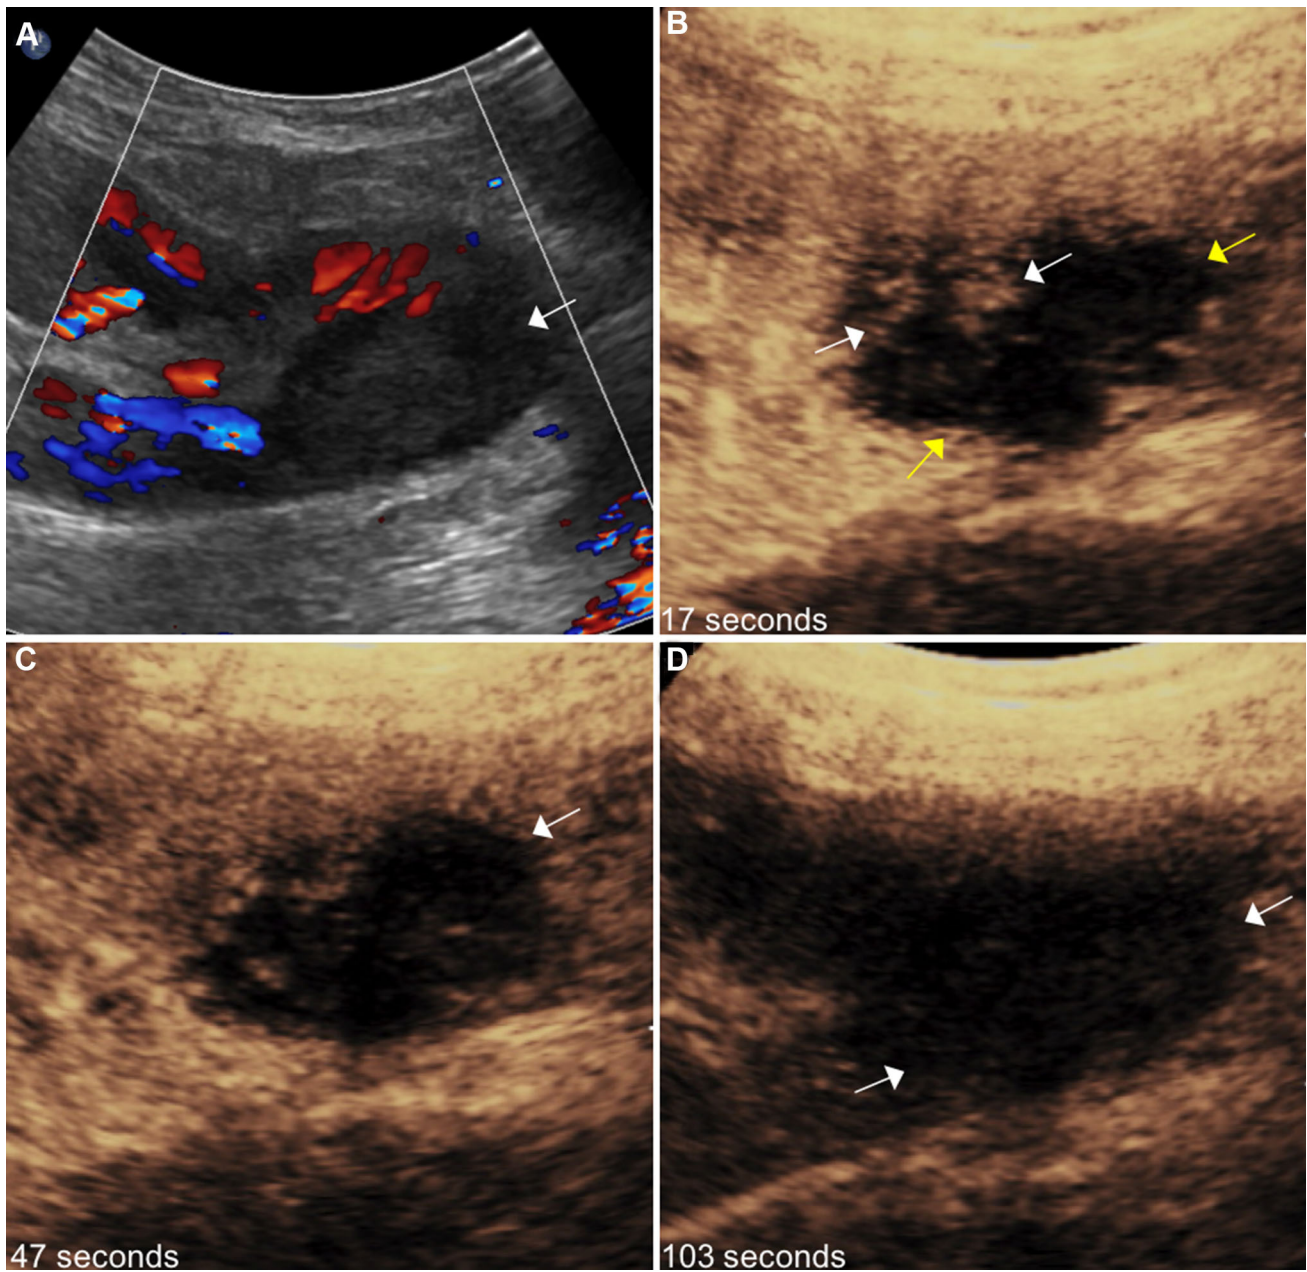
A 77-year-old male with history of right iliac fossa renal transplant. A Color Doppler ultrasound image demonstrates a round, hypoechoic mass at the lower pole of the transplant kidney without significant internal vascularity (*arrow*). B CEUS obtained in the arterial phase (17 s) demonstrates this mass to be predominantly hypoechoic (*yellow arrows*), with a few peripheral nodular areas enhancing to a
